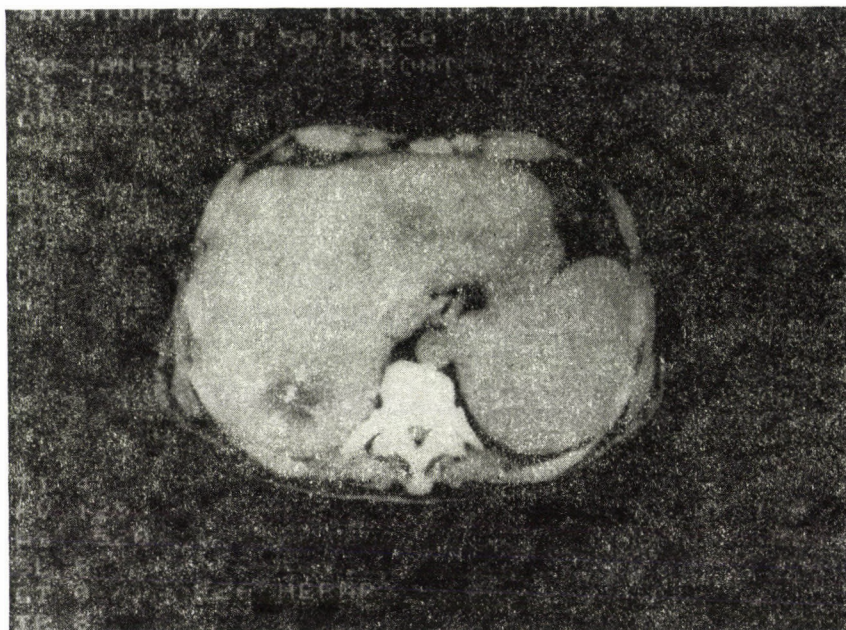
Control CT scan from ten days later. The two large abscesses have healed, with the drains removed. The third 2 by 3 cm abscess is clearly seen in segment VII
